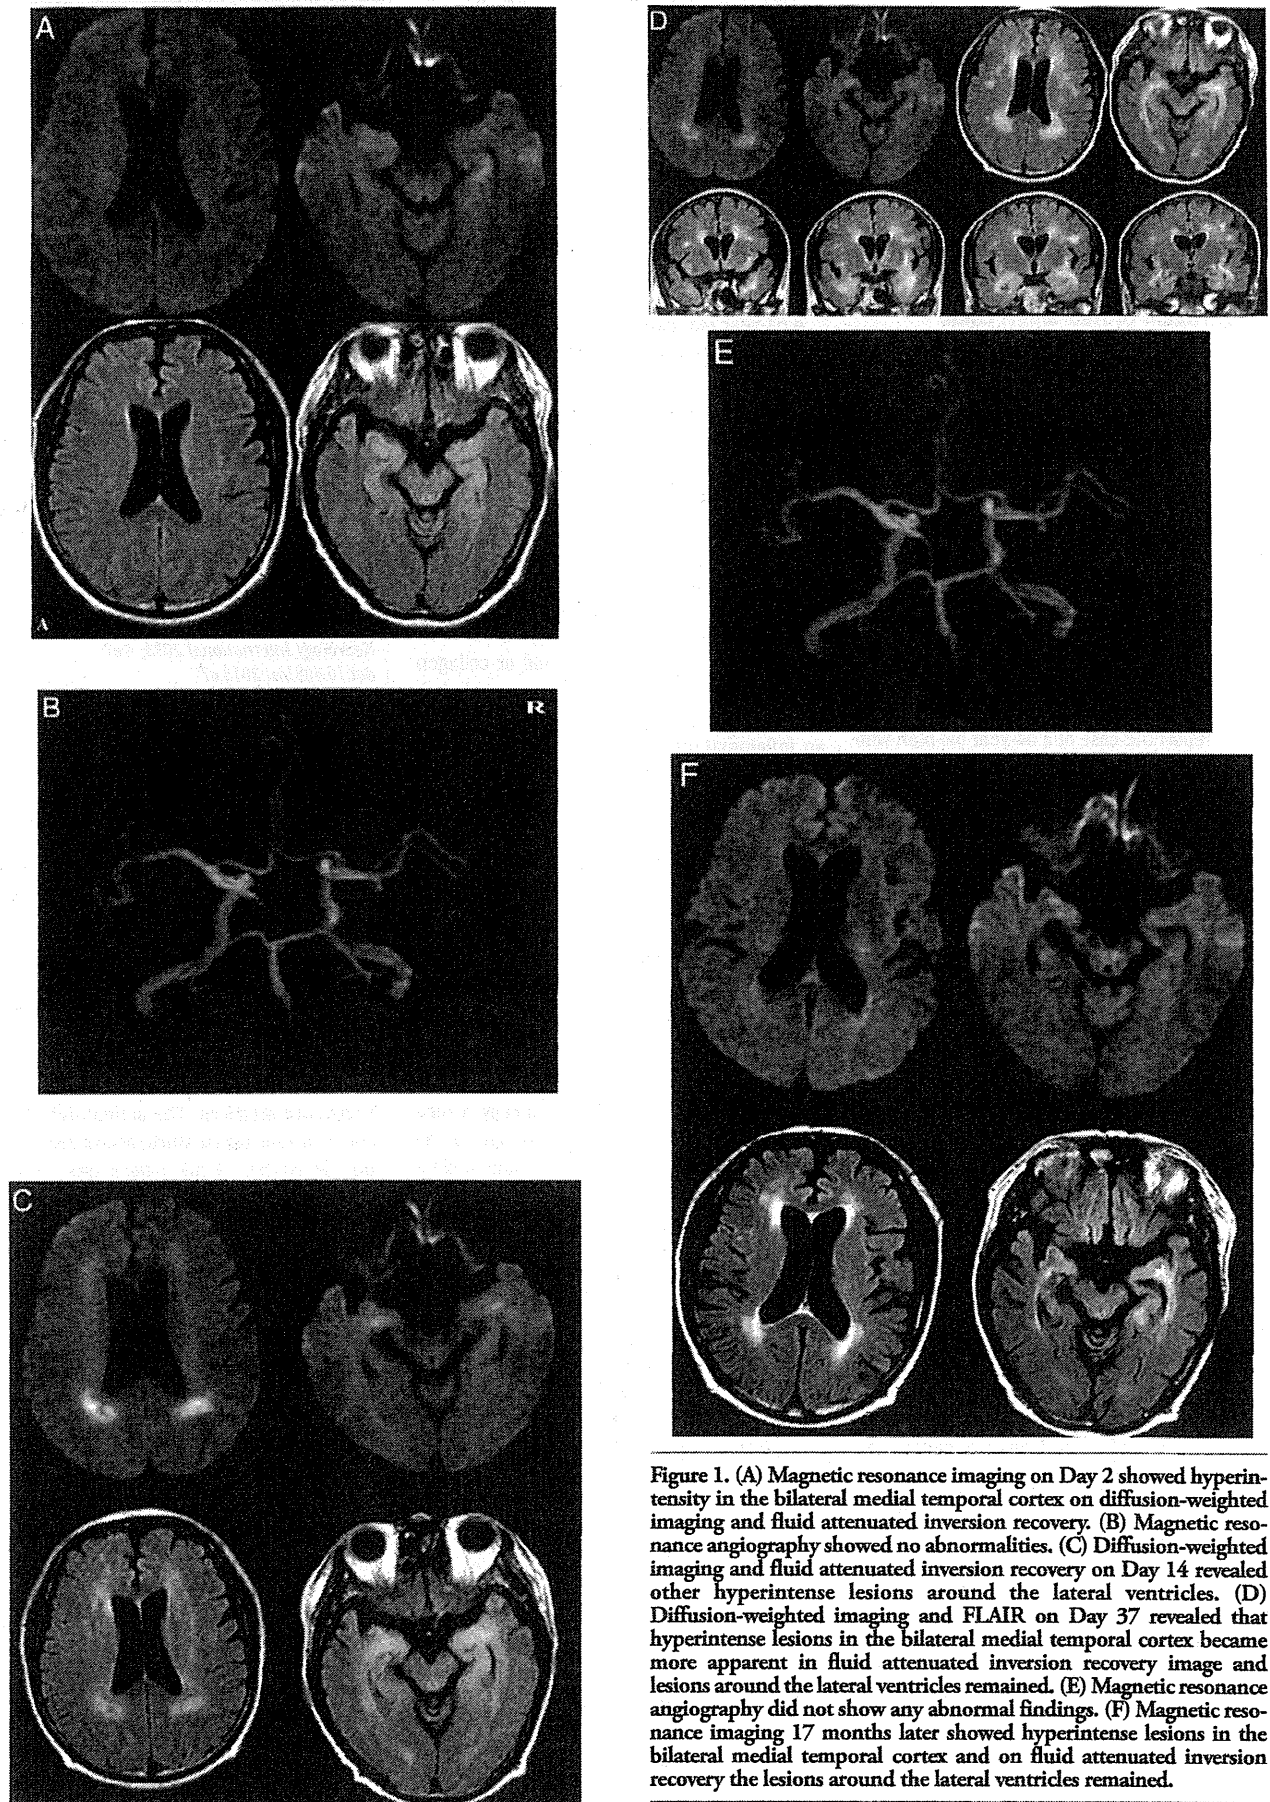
(A) Magnetic resonance imaging on Day 2 showed hyperintensity in the bilateral medial temporal cortex on diffusion-weighted imaging and fluid attenuated inversion recovery. (B) Magnetic resonance angiography showed no abnormalities. (C) Diffusion-weighted imaging and fluid attenuated inversion recovery on Day 14 revealed other hyperintense lesions around the lateral ventricles. (D) Diffusion-weighted imaging and FLAIR on Day 37 revealed that hyperintense lesions in the bilateral medial temporal cortex became more apparent in fluid attenuated inversion recovery image and lesions around the lateral ventricles remained. (E) Magnetic resonance angiography did not show any abnormal findings. (F) Magnetic resonance imaging 17 months later showed hyperintense lesions in the bilateral medial temporal cortex and on fluid attenuated inversion recovery the lesions around the lateral ventricles remained.
